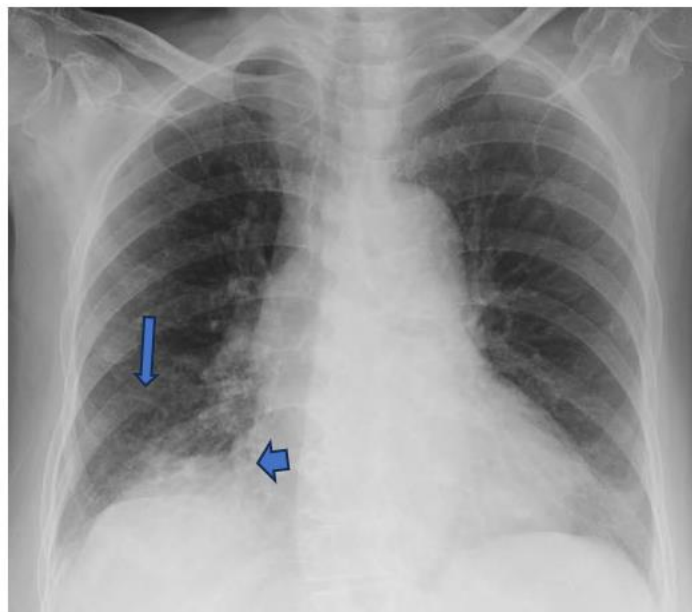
Second chest radiograph taken at day-16 of illness. Note the thickened bronchial walls (long-arrow) and segmental consolidation (short-arrow).
